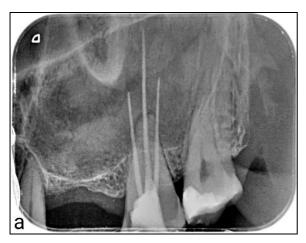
Pre-operative radiograph (gutta percha 5mm beyond apex)
